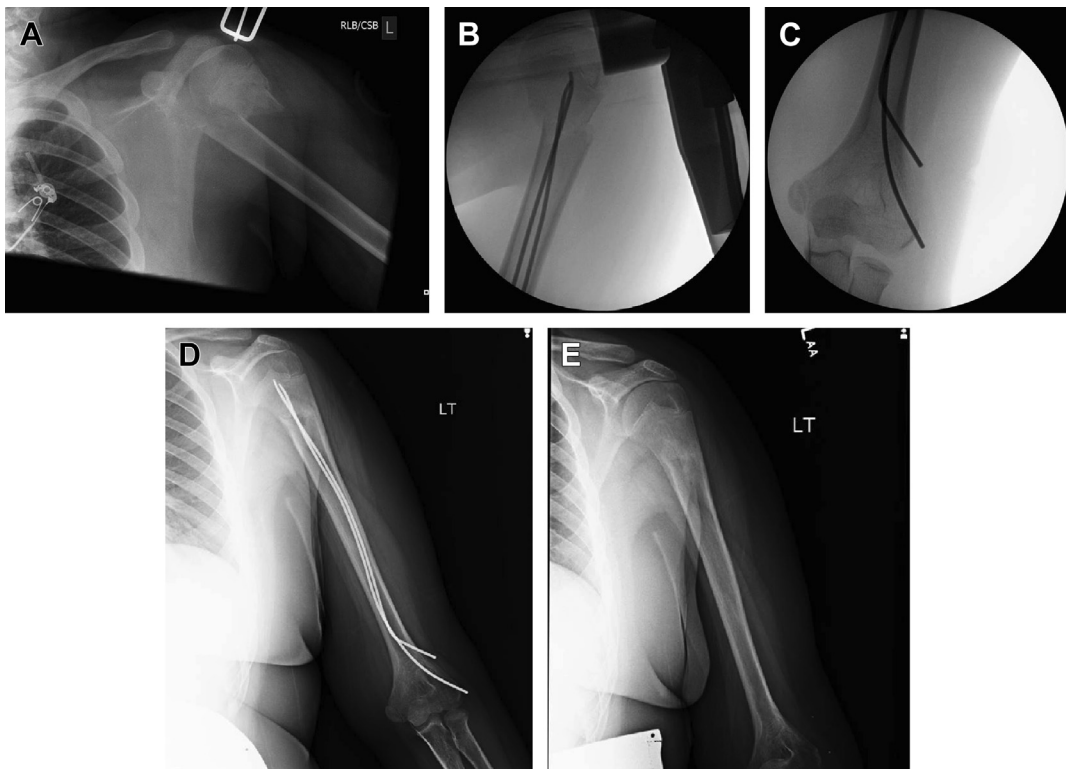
(A) A 13-year-old boy with shoulder pain after a fall during motocross. Radiographs show a displaced fracture of the proximal humeral metaphysis. (B) Fluoroscopic image of the proximal humerus taken during closed reduction and elastic nail fixation. (C) Appearance of the elbow during elastic nail placement. (D, E) Appearance of the proximal humerus at 6 months and after nail removal. The patient had regained full function and returned to sport.
